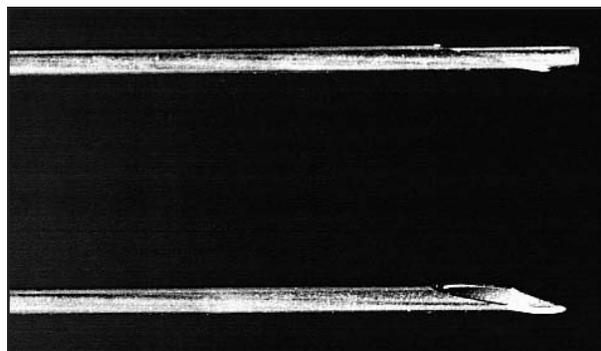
Bluntable vacuum tube blood-collection needle implemented at three hospitals (Punctur-Guard, Bioplexus Inc., Tolland, CT).
